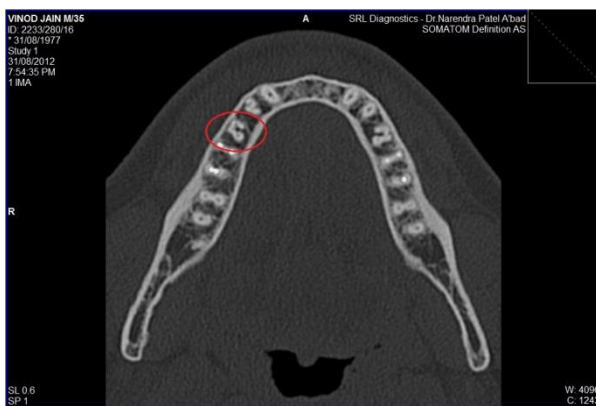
CT Scan Section showing root anatomy.
